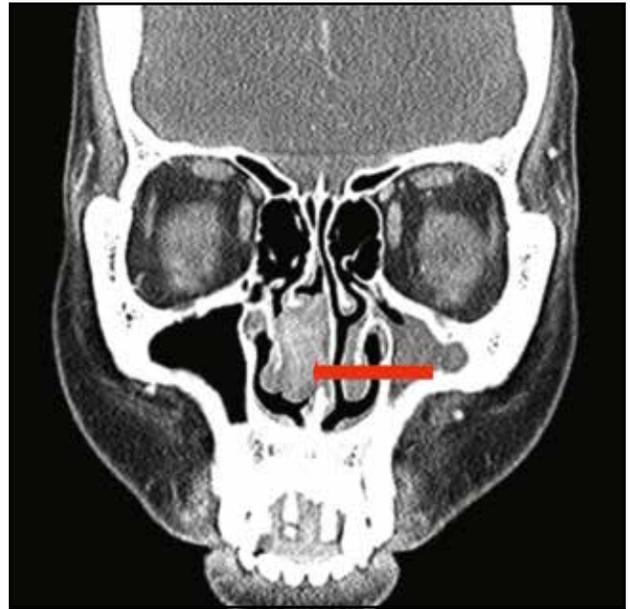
Cranio-facial CT scan showing the tumour arising from the septum.
